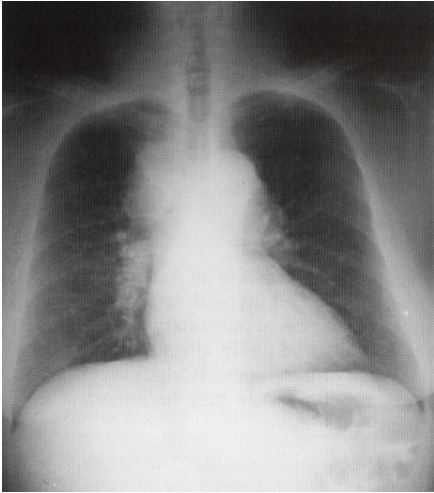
Chest radiograph of patient 1 showing mediastinal lymphadenopathy consistent with Stage I sarcoidosis.
